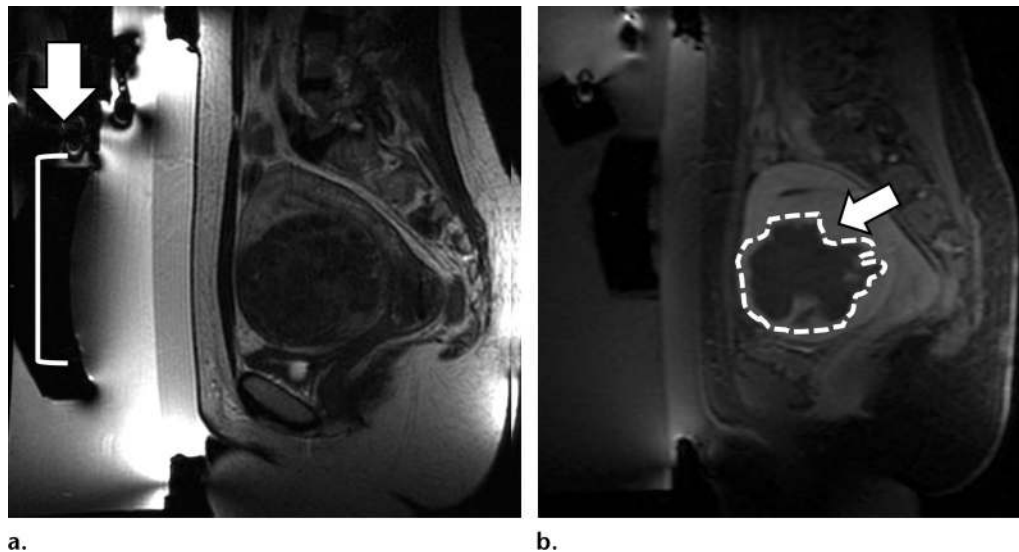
MR imaging–guided focused ultrasound for treatment of fibroids in a 31-year-old woman. (a) Sagittal T2-weighted image before treatment shows the location and size of the target uterine fibroid. The focused ultrasound device can be seen inferior to the patient (arrow, bracket). (b) Posttreatment sagittal gadolinium-enhanced T1-weighted fat-saturated image shows that more than 70% of the fibroid was effectively necrosed (dashed line). There is only a small rind of residual vascularized fibroid tissue at the posterior margin (arrow).
